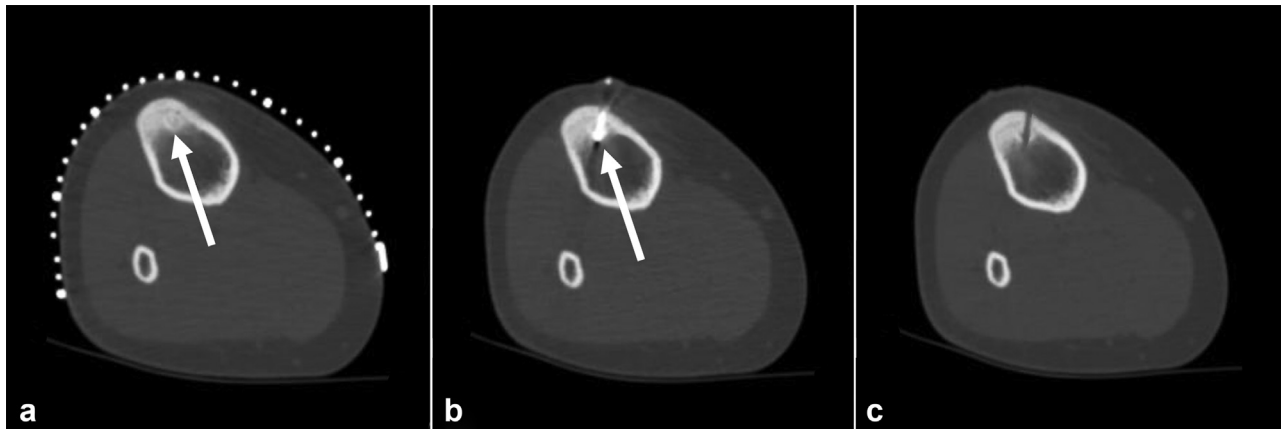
Subcortical osteoid osteoma of the tibia. (a) Axial CT image of the lesion (arrow). (b) A trocar and bone biopsy needle were used for access. After biopsy, a coaxial RF probe was inserted into the nidus (arrow). (c) Axial CT image immediately after ablation depicted the access route cortical defect through the nidus.
